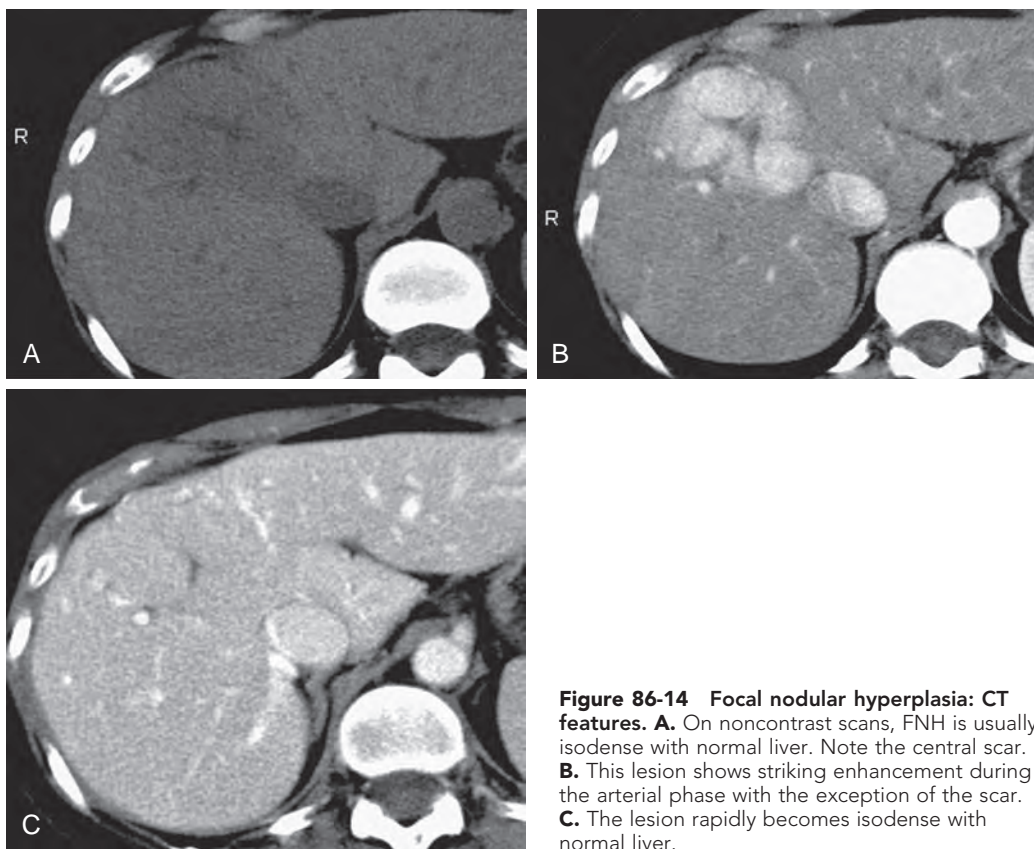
Focal nodular hyperplasia: CT features. A. On noncontrast scans, FNH is usually isodense with normal liver. Note the central scar. B. This lesion shows striking enhancement during the arterial phase with the exception of the scar. C. The lesion rapidly becomes isodense with normal liver.
